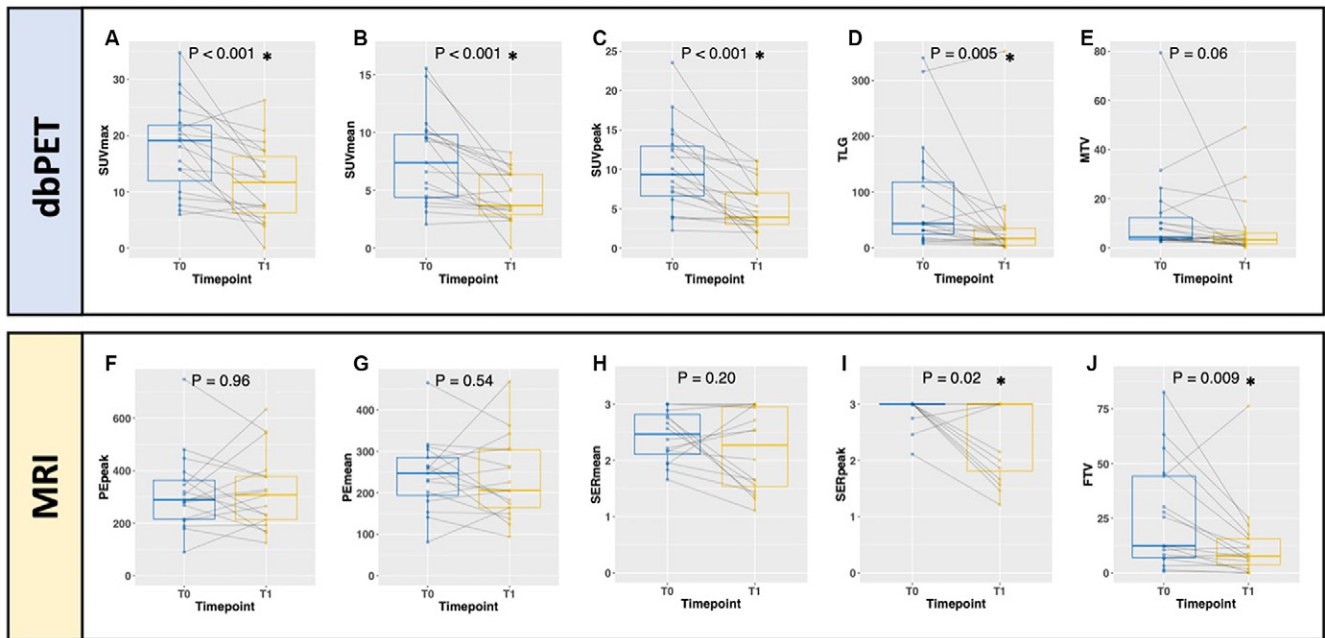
Box-and-whisker plots show comparison of parameters of fluorine 18 fluorodeoxyglucose uptake at dedicated breast PET (dbPET) and MRI parameters of the same lesion at T0 (week 0) and T1 (week 3). (A–E) dbPET parameters: (A) maximum standardized uptake value (SUV), (B) mean SUV, (C) peak SUV, (D) total lesion glycolysis (TLG), and (E) metabolic tumor volume (MTV). (F–J) MRI parameters: (F) peak percent enhancement (PE), (G) mean PE, (H) mean signal enhancement ratio (SER), (I) peak SER, and (J) functional tumor volume (FTV). The boundaries of the boxes indicate the lower and upper quartiles, the lines within the boxes indicate the medians, and the whiskers indicate the range (not including outliers). Gray lines connect the data for individual lesions. * = $P < .05$.
